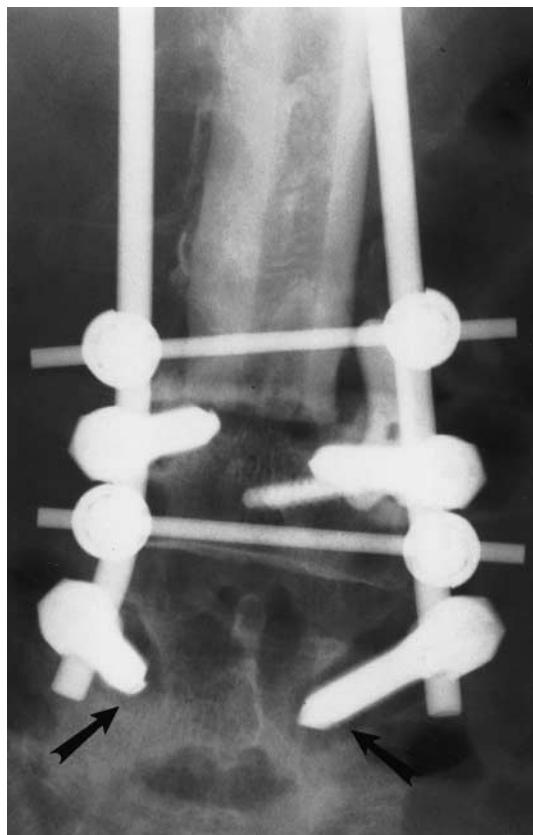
Case 17. Plain x-ray film demonstrating subsidence of bone around pedicle screws with evidence of reinfection (arrows).
